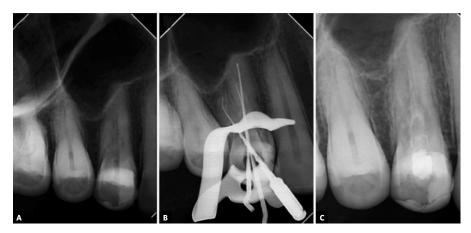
A) Initial periapical radiograph; B) Odontometry; C) Dressing with calcium hydroxide (Nov/2013).
